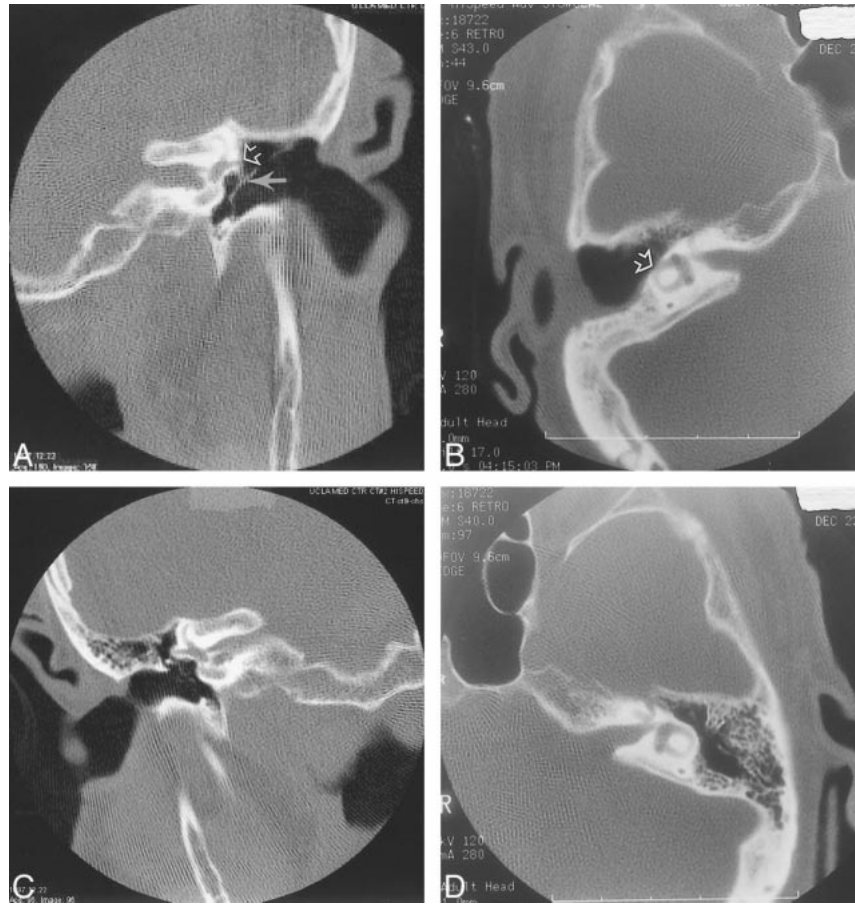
CT scans of the temporal bones in an 87-year-old woman with a history of temporal bone surgery performed in the early 1940s.
